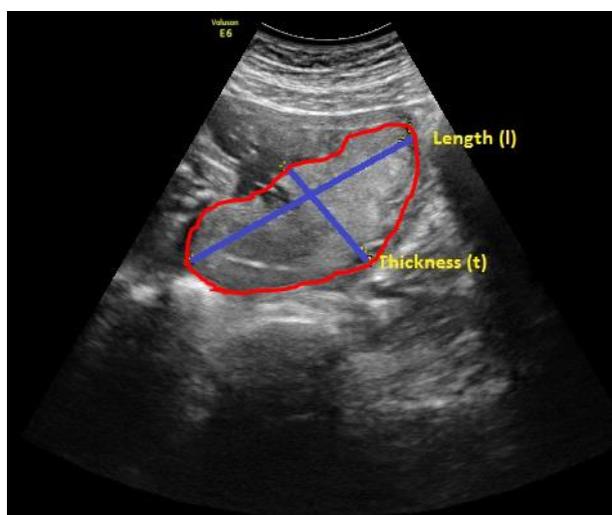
Measurement of In-Utero Placental Biometry using 2D ultrasound. Maximal placental thickness (t) and maximal placental length (l) indicated. Placenta delineated in red.
